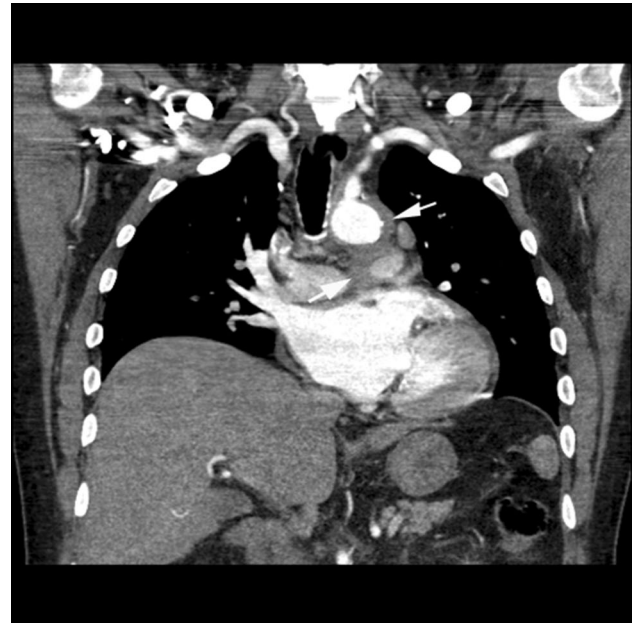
60-year-old woman with Takayasu arteritis. Coronal chest CT demonstrates mural thickening involving the aorta (arrow) and pulmonary artery (arrow)
